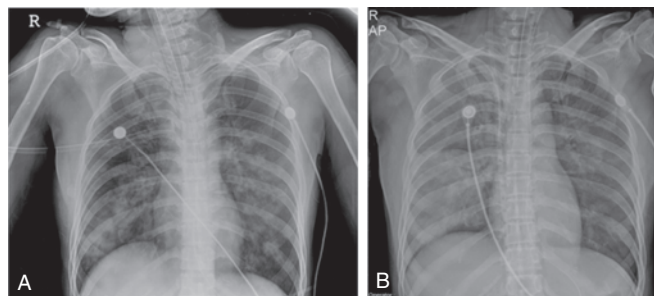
Chest X-rays at the time of admission (A) and after 4 hours (B)
